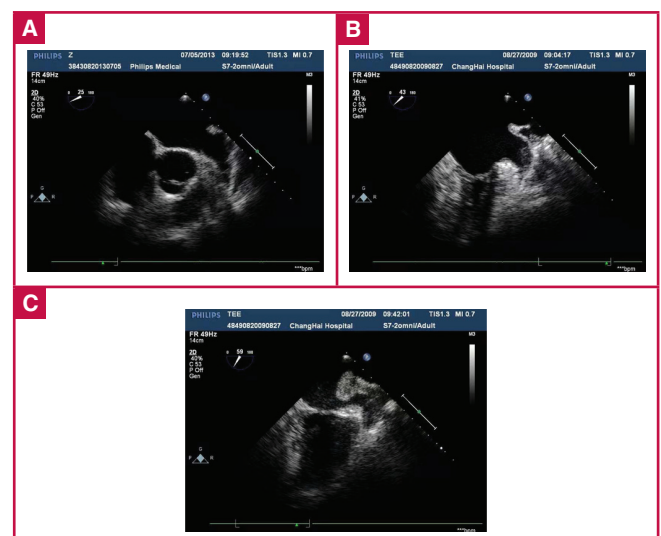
Spontaneous ultrasound imaging of different changes of blood in the LA/LAA. A: with mud variation in the LAA, B: with thrombus variation in the LAA, C: without mud or thrombus variation in the LAA.
